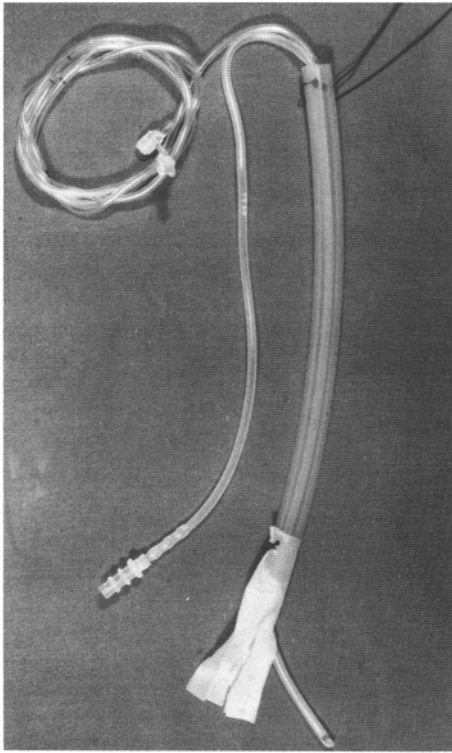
Silastic transesophageal tutor
